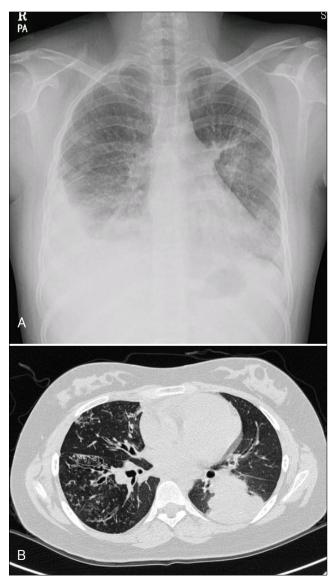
(A) Chest radiography (B) Chest computed tomography (CT) scan showing both lower lobe pneumonia with underlying bronchiectatic change.
